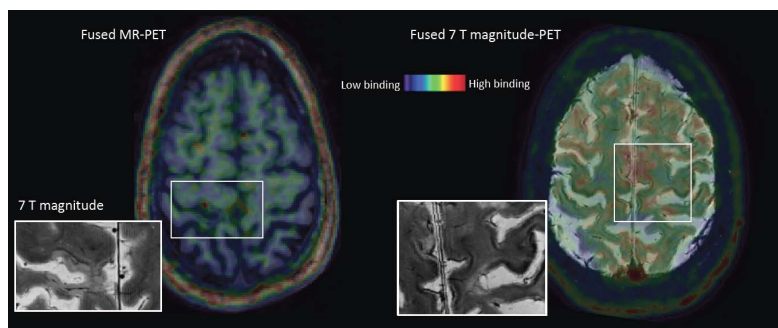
Summed [¹¹C]-PBR28 PET images coregistered and fused with the 3 T MEMPR anatomical from a male (left) and from the 7 T magnitude image from a female (right) subject with SPMS demonstrating areas of increased radiotracer SUV, which appear topographically associated with the presence of cortical lesions on the coregistered 7 T T2* magnitude images in both patients.
